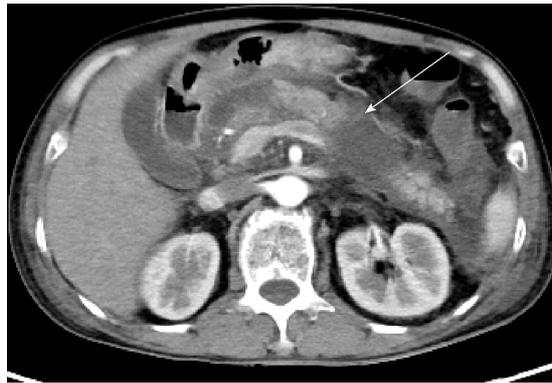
Contrast-enhanced computed tomography revealed necrotizing pancreatitis (as shown by the arrow).
